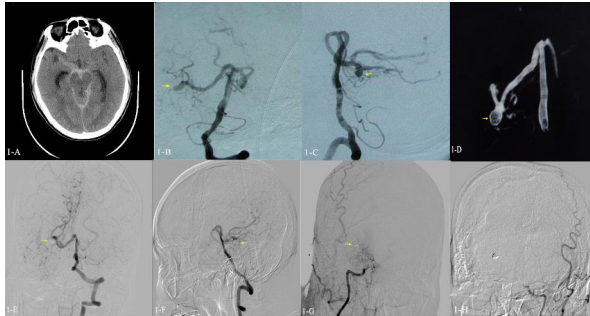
CT scan shows subarachnoid hemorrhage in suprasellar cistern and cisterna ambiens, 1-B, C, D: Right vertebral angiograms shows a 3-mm saccular aneurysm at left P2 segment of posterior cerebral artery (1-B: Frontal view, 1-C: Lateral view, 1-D: 3D reconstruction view); 1-E, F: Right vertebral angiogram shows occlusion of aneurysm with coils (1-E: Frontal view, 1-F: Lateral view), 1-G, H: carotid angiograms shows obstruction at the terminal portion of internal carotid artery and moyamoya vessels. (Arrow point to aneurysm).
